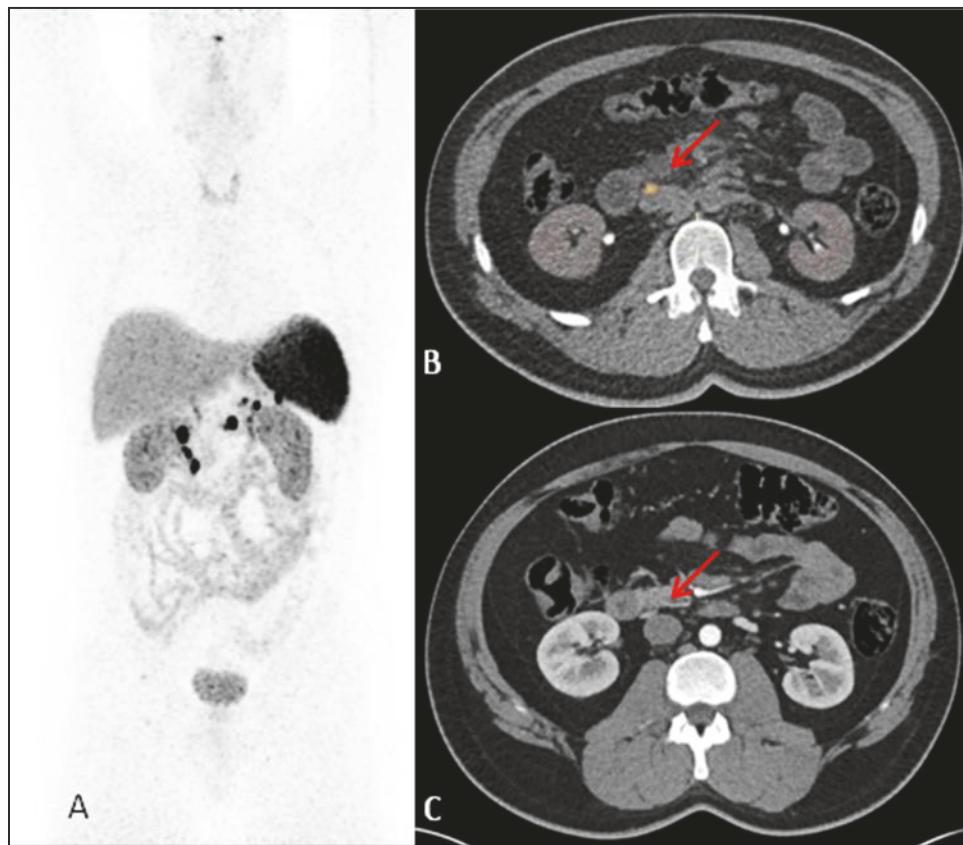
Example of a patient with MEN-1, 32 year old male, who has known pancreatic lesions, and was found to have a retropancreatic lymph node on $^{68}\text{Gallium}$ -DOTATATE PET/CT ($\text{SUV}_{\text{max}} 79$) (Figure 2A and B, arrow). This lesion was not clearly visible and not described as abnormal on a pancreatic protocol CT scan (Figure 2C, arrow) and would be difficult to follow.
